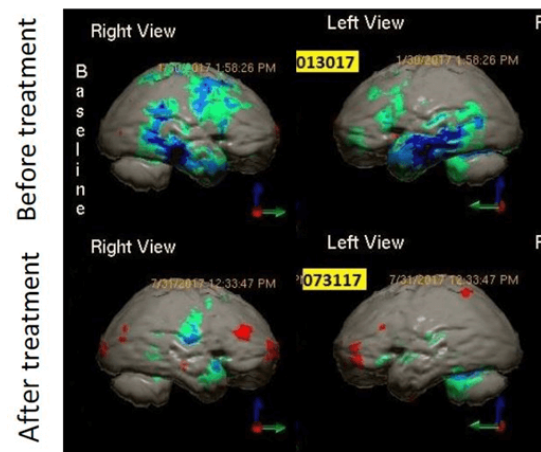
Pre- and posttreatment SPECT scans in patients with TBI after a fall from a truck at freeway speed. Areas of decreased perfusion (function) in green, light blue, and dark blue show improvement after multi-Watt NILT. Color scale based on comparison to a normative database (Segami Corp) in which areas of grey are within 2 standard deviations (SD) of the mean cerebral blood flow of the normative database. Green, 2 to 3 SD below mean; light blue, 3 to 4 SD below mean; dark blue, 4 to 5 SD below mean; red, 2 to 3 SD above mean.
